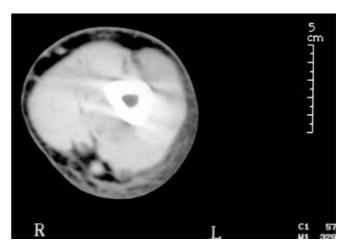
Severe subcutaneous edema on CT scan of the forearm
